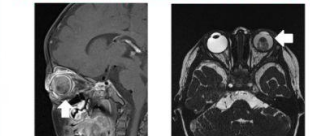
(left) Oblique sagittal T1-weighted post-contrast MRI image and (right) axial T2-weighted MRI image of a 13-month-old boy with left eye retinoblastoma. There is increase in contrast enhancement in periorbital soft tissue in left eye involving posterior to the orbital septum (arrow), suggestive of orbital cellulitis. There is also posterior subluxation of left lens shown in the T2-weighted image (arrow).
